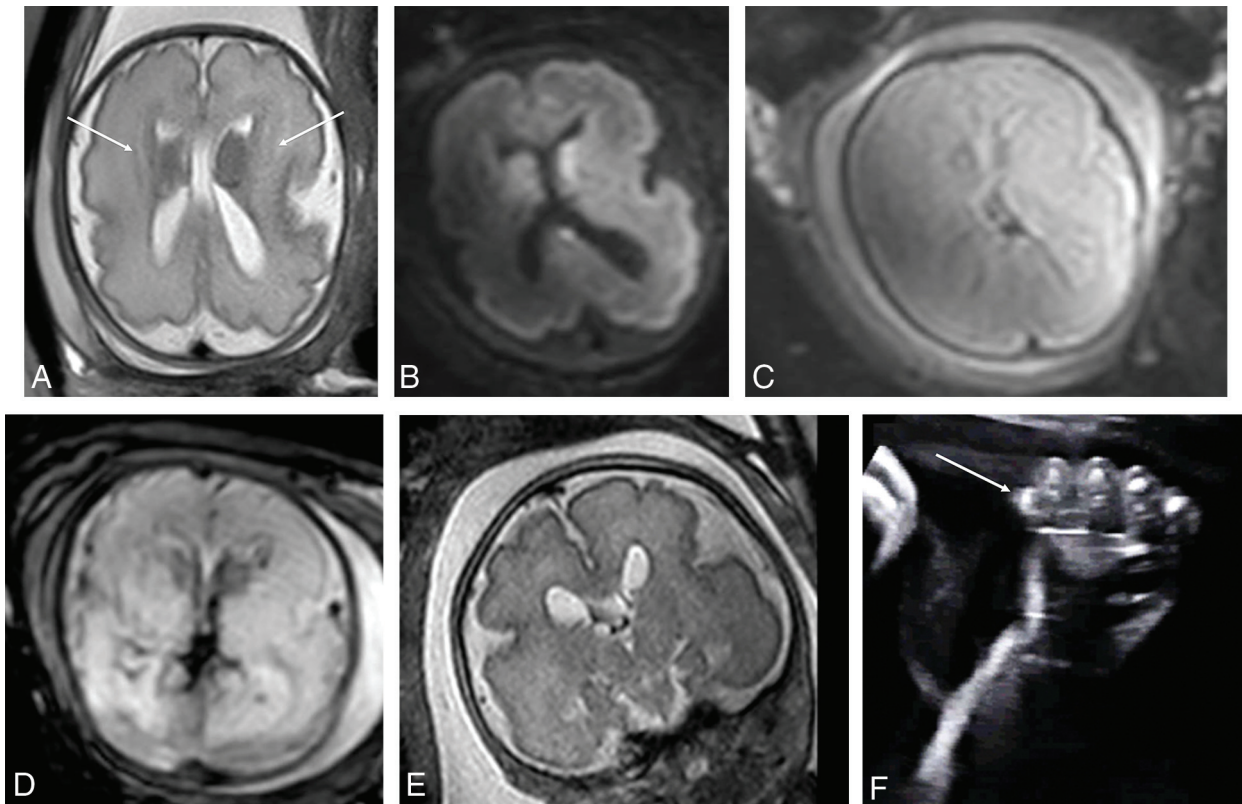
PIK3CA* pathogenic variant. Case 2 at 31 weeks 3 days' gestation. Megalencephaly, polymicrogyria, polydactyly hydrocephalus syndrome due to a *PIK3CA* heterozygous pathogenic variant. The fronto-occipital diameter is >6 SDs above the mean for gestation. Enlarged bilateral ganglionic eminences (arrows, A) are seen on T2-weighted single-shot FSE and DWI (A and B). Diffusion-weighted $b = 0$ image (C) and T2*-weighted EPI (D) confirm the absence of hemorrhage as the cause for ganglionic eminence enlargement. Abnormal opercularization is present with Sylvian fissures lined by peri-Sylvian polymicrogyria (E). Postaxial polydactyly is seen on sonography with arrow indicating a rudimentary sixth digit medial to the fifth digit of the hand (F).
